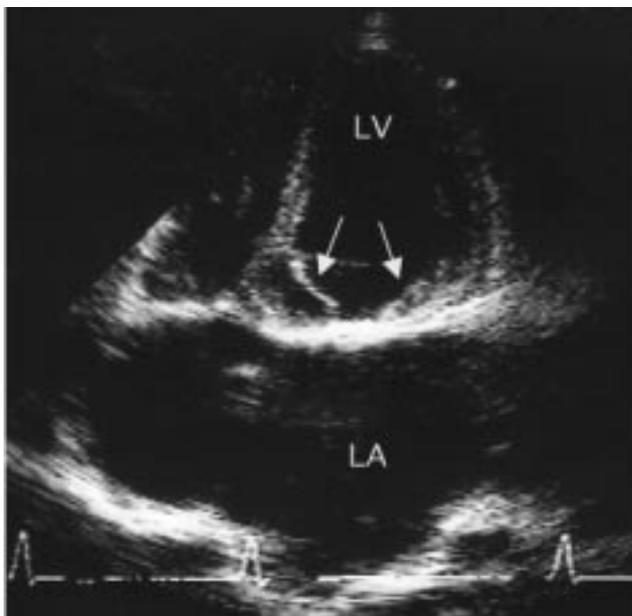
Preoperative transthoracic echocardiogram in patient 1. LV, left ventricle; LA, left atrium. Arrows: cloth wear.
